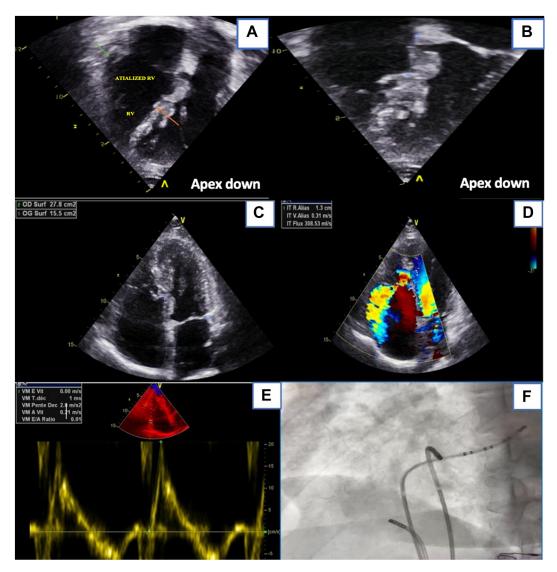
(A, B) Apical 4-chamber view reveals significant apical displacement of the septal tricuspid leaflet (orange arrow) relative to the anterior mitral leaflet (green arrow), leading to atrialization of the right ventricle. (C) Apical 4-chamber view demonstrates pronounced enlargement of the right atrium. (D) Color-flow Doppler shows evidence of severe tricuspid valve regurgitation. (E) Longitudinal systolic function of the right ventricle appears normal based on S' wave and isovolumic acceleration. (F) Position of catheters during an electrophysiology study. We note the massively enlarged right heart with the displaced tricuspid annulus and the distortion of anatomic landmarks, making the procedure difficult.
